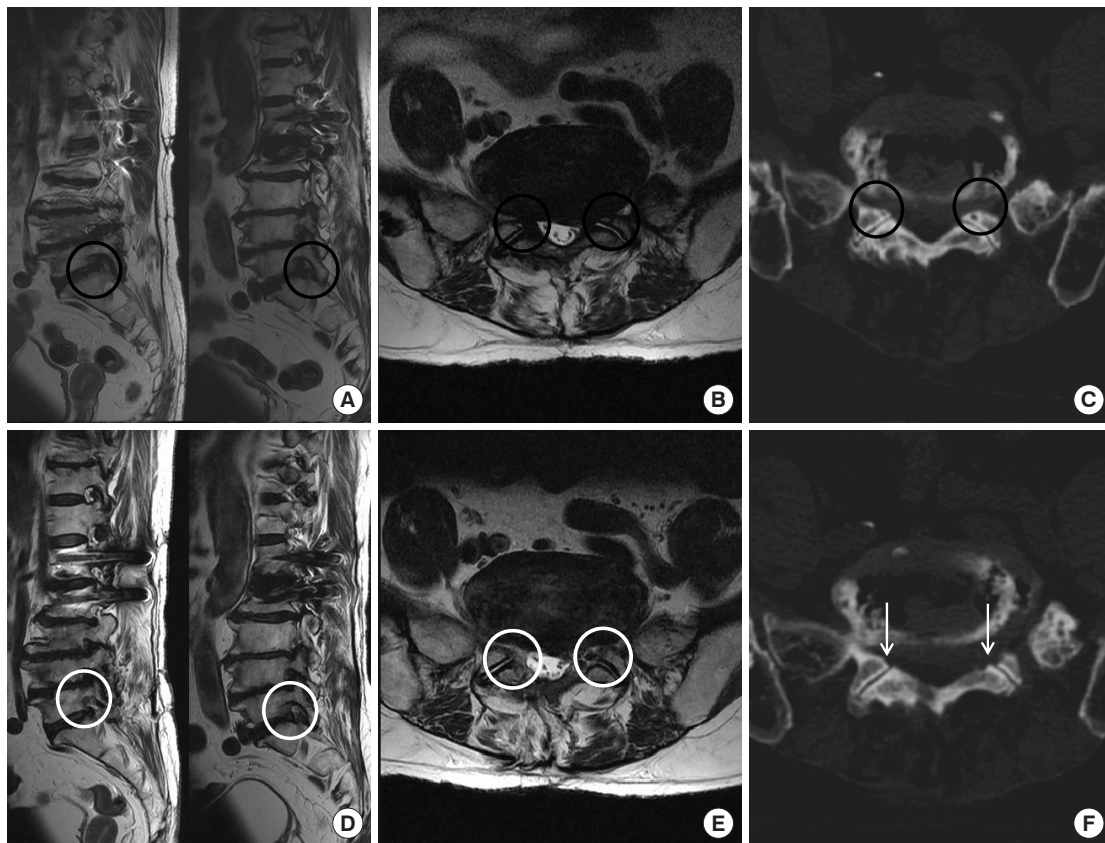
Pre- and postoperative radiologic images of the second case. (A) Preoperative parasagittal T2-weighted magnetic resonance imaging (MRI) image. (B) Preoperative axial T2-weighted MRI image. (C) Preoperative axial computed tomography (CT) image. (D) Postoperative parasagittal T2-weighted MRI image. (E) Postoperative axial T2-weighted MRI image. (F) Postoperative axial CT image. Black circles: compressed areas of bilateral L5 nerve root by L5–S1 foraminal stenosis. White circles: decompressed foraminal areas for bilateral L5 exiting roots. White arrows: resected areas of bilateral superior articular process of S1.
